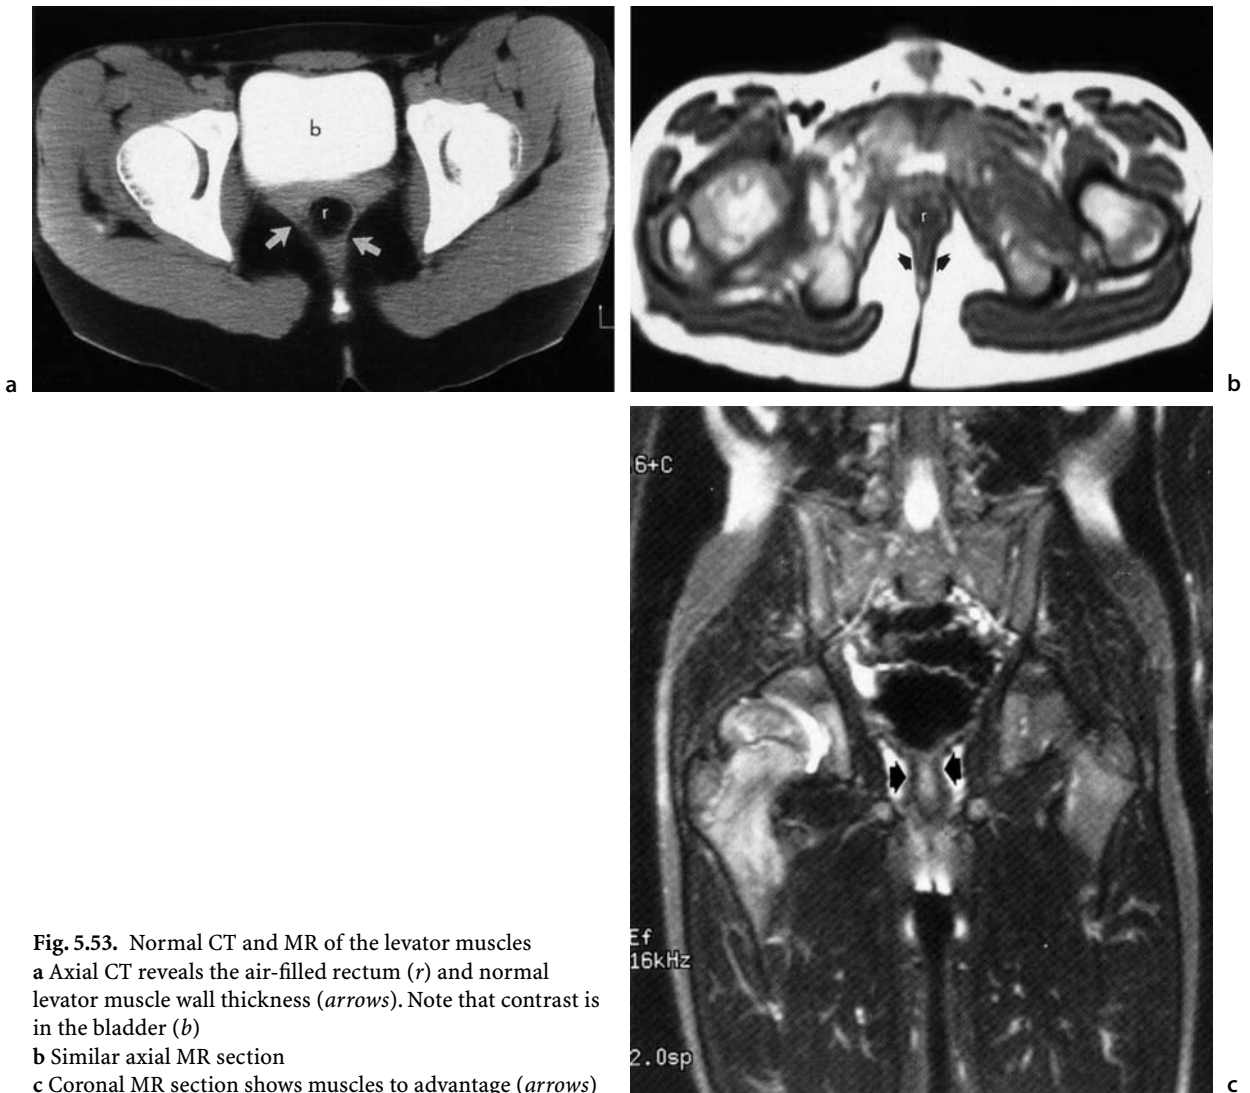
Normal CT and MR of the levator muscles
